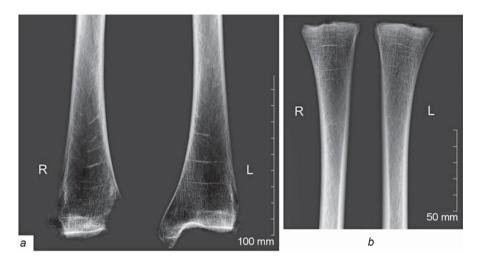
X-ray images of the tibiae with Harris lines (orthogonal projection). a – distal parts (burial 324); b – proximal parts (burial 287).
